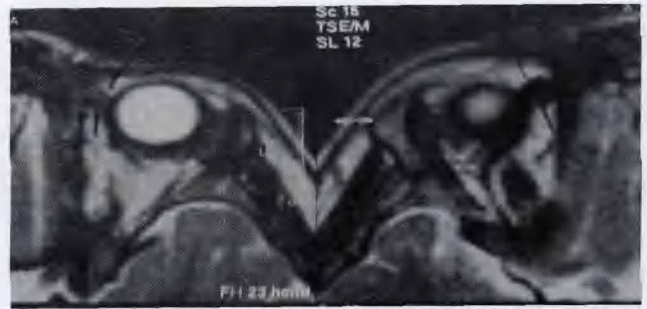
Increased SO tendon width of RE-LE in MRI
